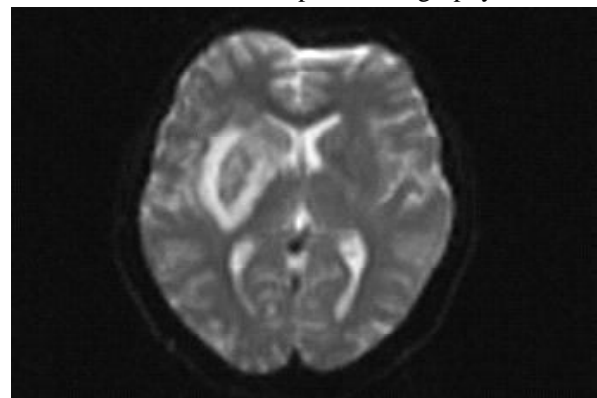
MRI Brain with DWI image showing acute infarct right capsuloganglionic region
